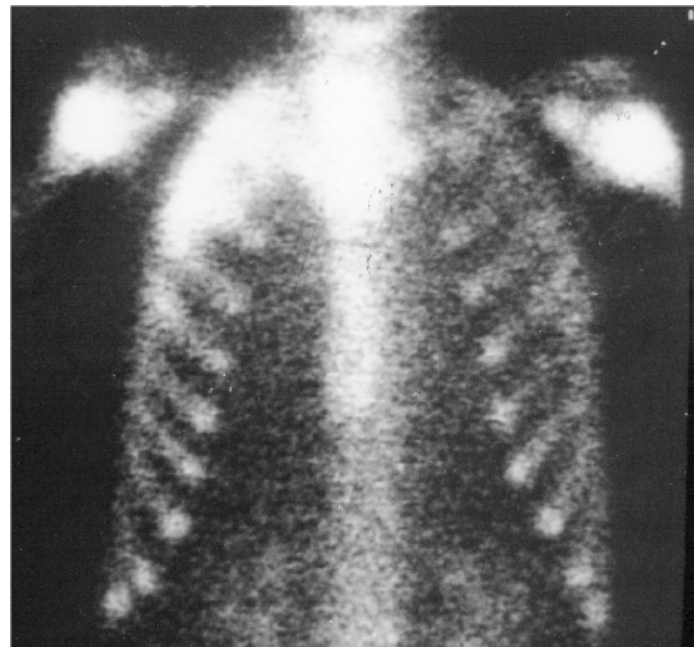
Bone scintigraphy showing intense hyperfixation in the right upper lobe.
